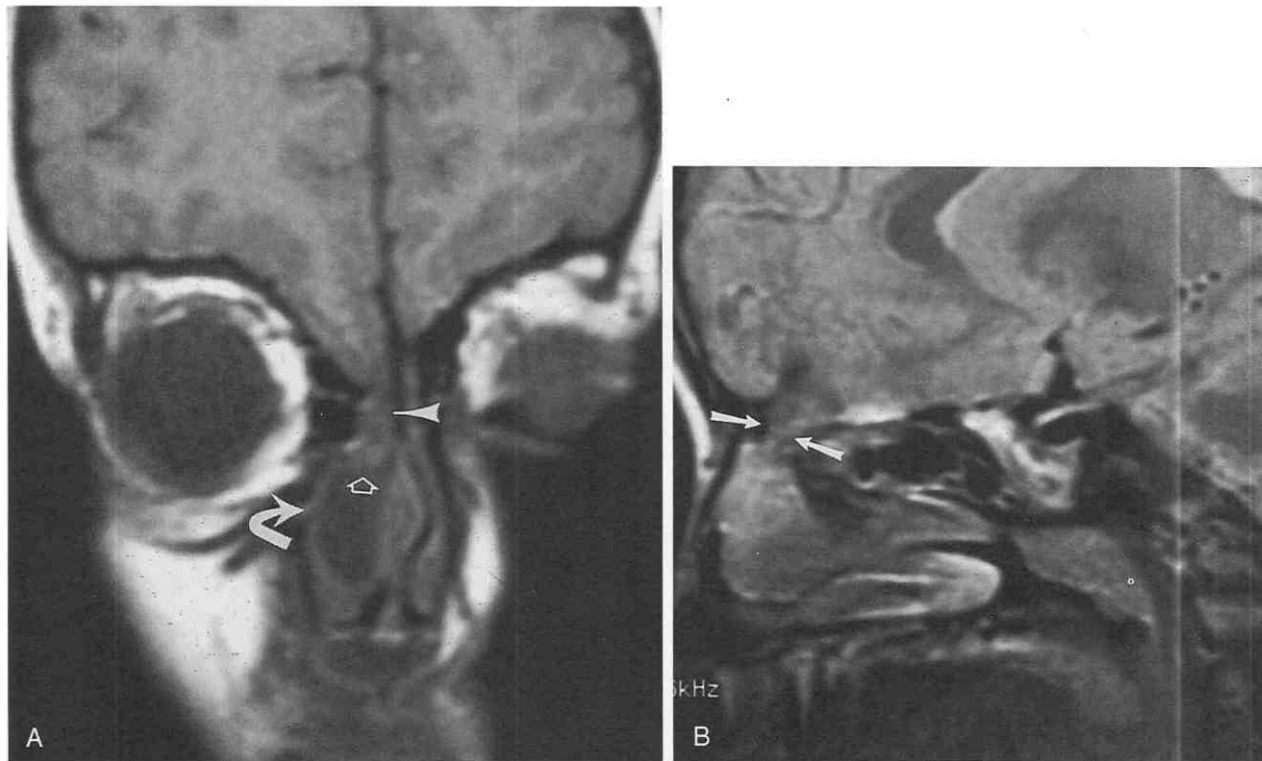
Trans(fronto)ethmoidal encephalocele. *A*, Coronal T1-weighted MR image shows inferior displacement of the right gyrus rectus, with continuity of neural tissue extending through the foramen cecum (arrowhead) and into the right anterior nasal cavity (curved arrow). The mass contains a small amount of neural tissue (arrowhead) in addition to cerebrospinal fluid. *B*, Sagittal intermediate-weighted image demonstrates extension of the neural tissue through the foramen cecum (arrows).
